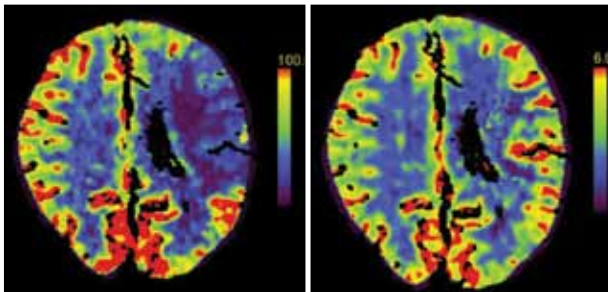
CT axial perfusion images. Color blood flow is reduced in the right hemisphere; color blood volume is maintained, suggesting viable brain tissue. The black area is the right ventricle containing cerebrospinal fluid.
